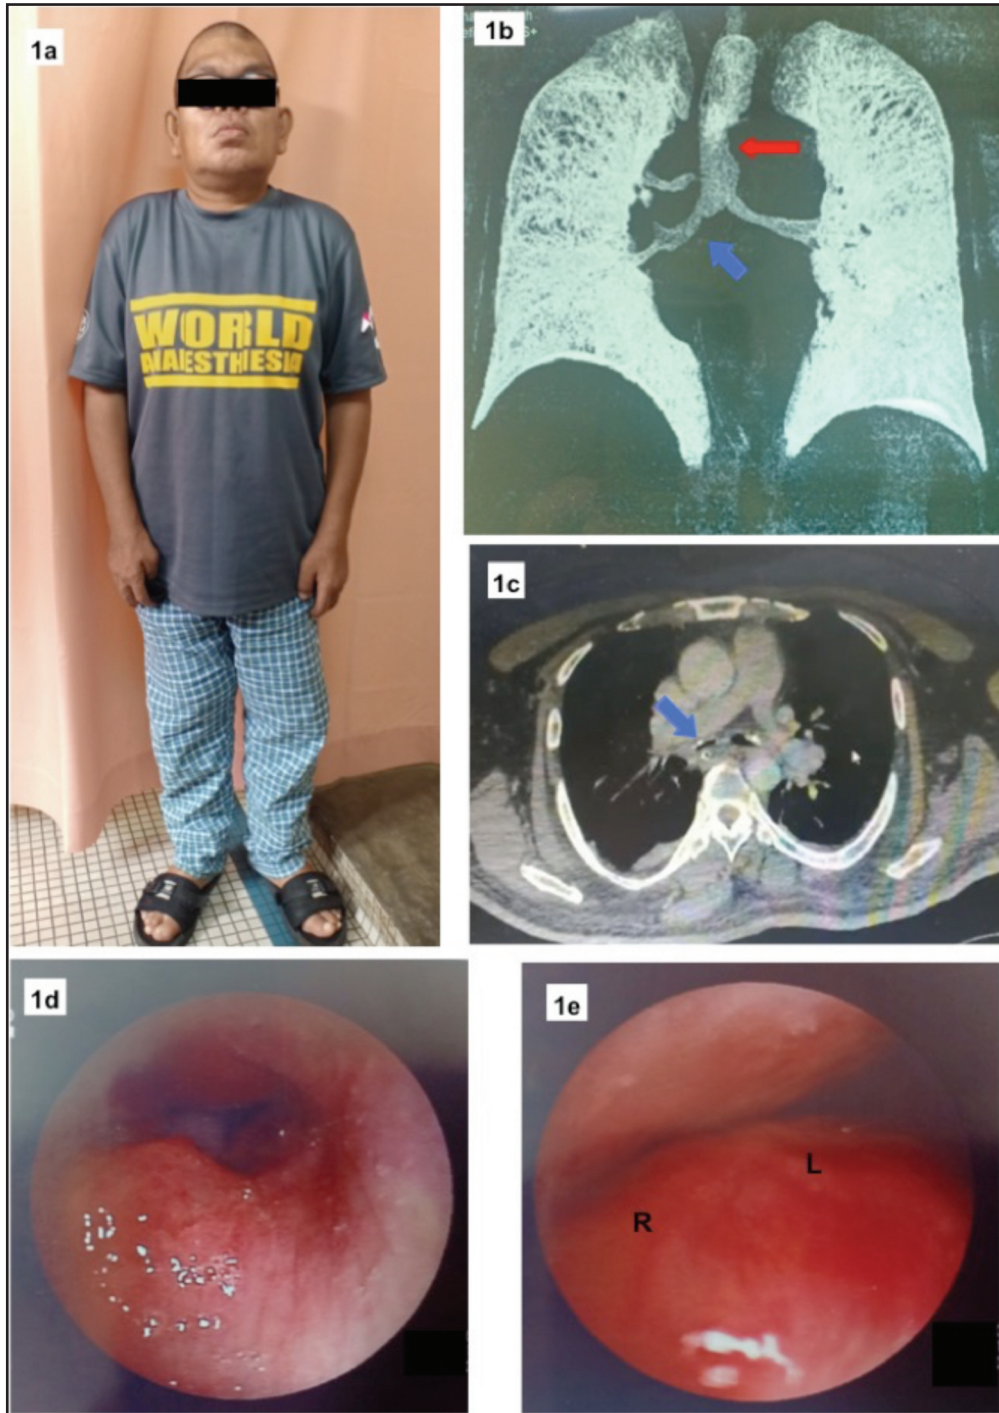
a) The patient's height is 155cm. He has thick neck and course facial features, which is suggestive of mucopolysaccharide syndrome. Publication of the patient's photo was permitted and consented by the patient b,c) CECT Thorax and reconstruction CT revealed a collapsed trachea (red arrow) inferior to the tracheostomy tube with anterior-posterior diameter of 0.7cm. Both main bronchi are also stenotic, more severe on the right (blue arrow). d) Bronchoscopy through the nasal cavity showed oedematous nasopharynx and the trachea proximal to the tracheostomy tube was narrowed with presence of granulation tissue e) Lower third of the trachea and bilateral main bronchi were stenotic. As seen during bronchoscopy, right main bronchus (R) was narrower compared to left main bronchus (L).
